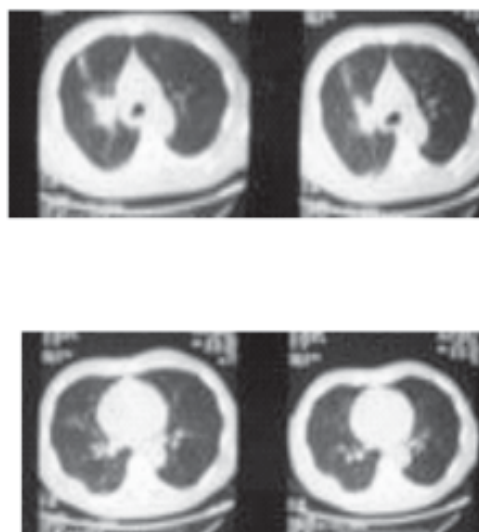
CT chest X-ray.
